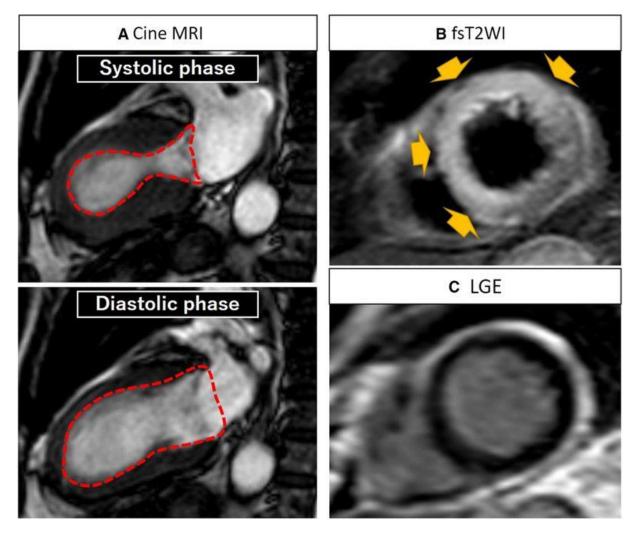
CMR imaging of Takotsubo Syndrome. (A) Wall motion abnormalities at the mid-ventricular to apical anterior segments with cine imaging as apical ballooning. High signal intensity with fat-saturated T2-weighted images (fsT2WI) (yellow arrows) due to the myocardial oedema (B), but the absence of the late gadolinium enhancement (LGE) (C) are shown. Reprinted with permission from Manabe *et al*, 2018¹¹⁶
